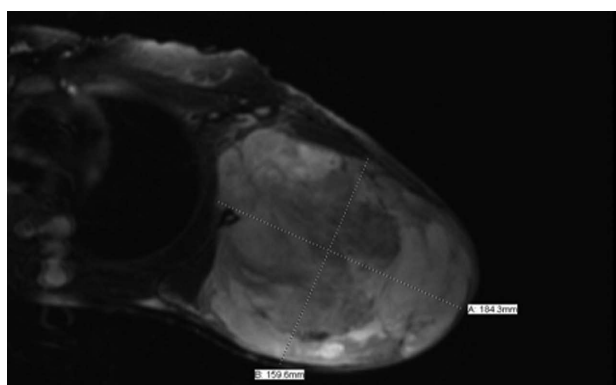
Magnetic resonance imaging of left shoulder, Mass: 18.4 cm × 15.9 cm × 20 cm.
